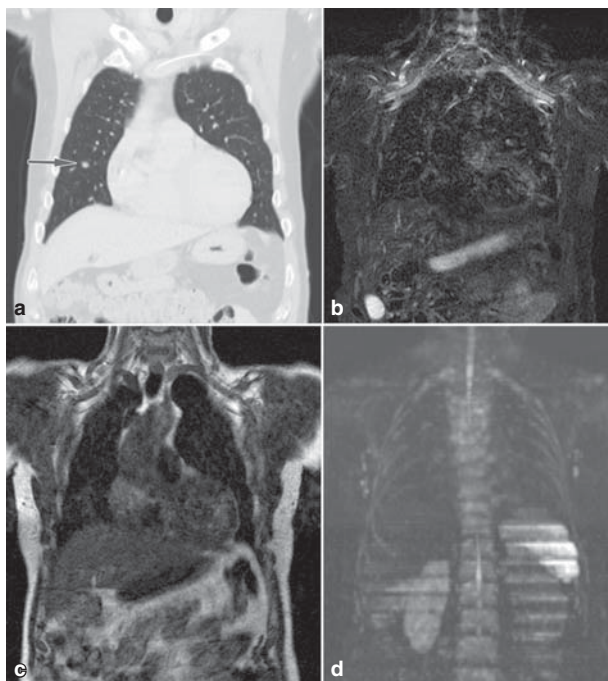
A 66-year-old man with multiple malignant melanoma metastases. The CT image, coronal reconstruction, showed a lesion in the right lung (arrow) measuring approximately 7 mm in longest diameter (a). The lesion was not detectable on STIR and T1 images (b and c). The lesion could not be detected on coronal maximum intensity projection (MIP) DWI image (d). The lesion was not detected on axial DWI (not shown).
